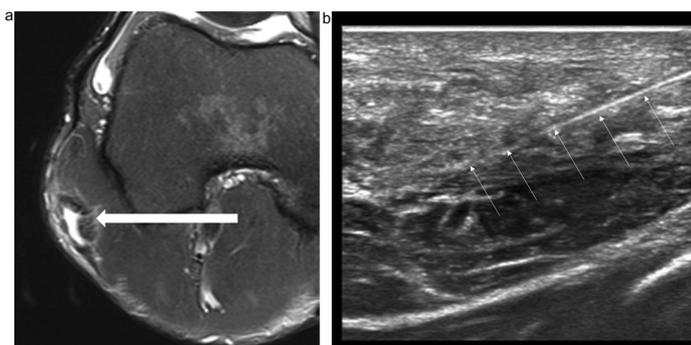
31-year old male rugby player 2 weeks post distal biceps tendon injury. (a) Axial STIR MRI showing injury to the distal biceps femoris tendon with intra-substance delamination (arrow). (b) Axial sonogram showing 21 gauge needle insertion for PRP injection into tendon (small arrows).
